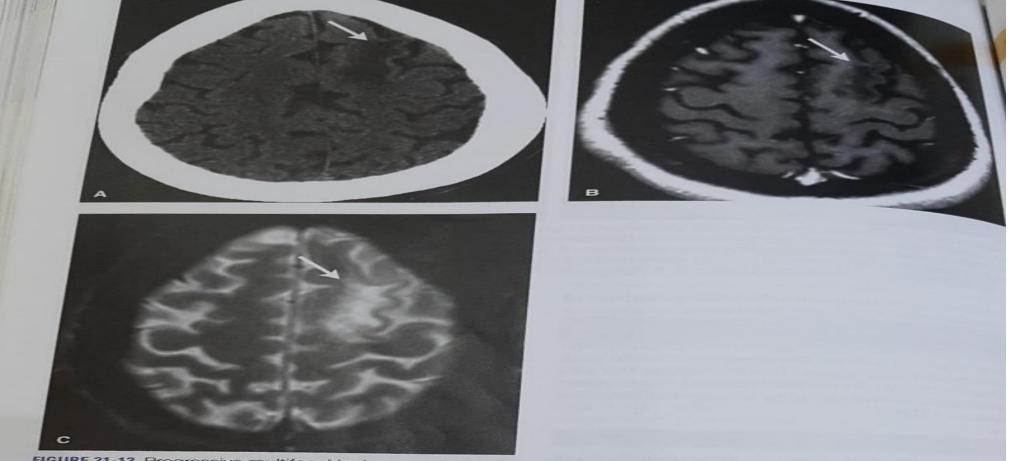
Progressive multifocal leukoencephalopathy: (A) axial CT; (B) postcontrast T1-weighted MRI; (C) T2-weighted MRI. Images show a subcortical focus of abnormality within the high left frontal lobe (arrows), corresponding to the motor association region. The characteristic features of this demyelinating process included by T-cell count reflecting an immunocompromised status is also key to the diagnosis. In an immunocompete syndrome, which can have a similar appearance. [CT, computed tomography; MRI, magnetic resonance image (Reprinted with permission from Brant WE, Helms C. Fundamentals of Diagnostic Radiology. 4th ed. Philadel
